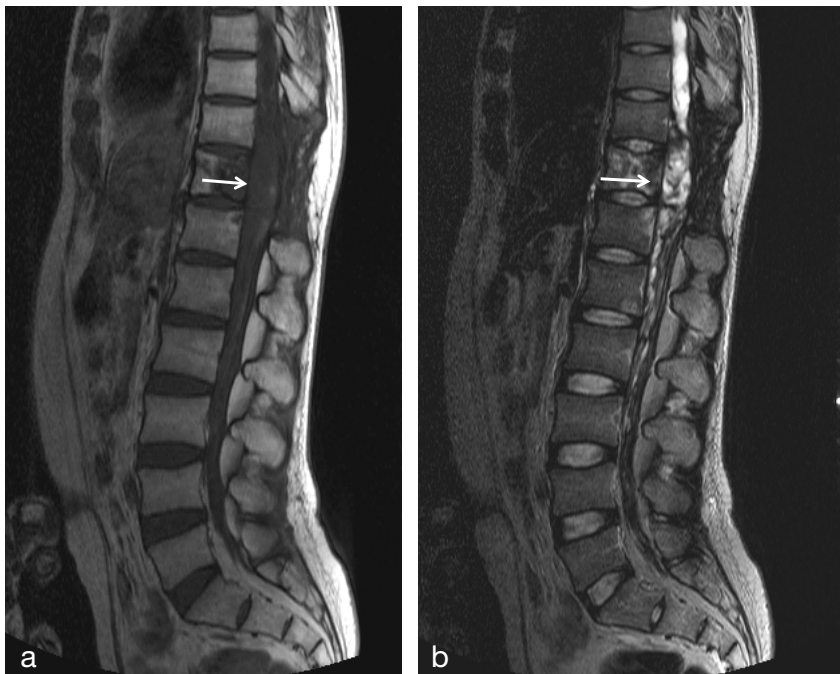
Post-chemotherapy magnetic resonance imaging (MRI) findings. Sagittal view of (a) T1-weighted and (b) T2-weighted images. MRI revealed a remaining tumor presenting as a heterogeneous signal intensity at the Th11 level (arrows).
